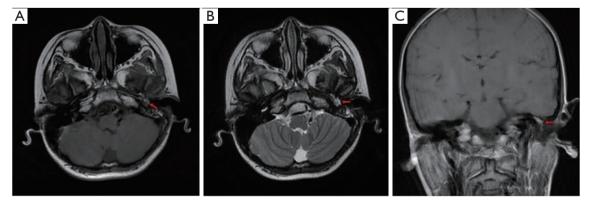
Preoperative MRI. (A) *T1WI*, axial. (B) *T2WI*, axial. (C) Enhanced *T1WI*, coronal. The red arrow indicates the lesion site. MRI, magnetic resonance imaging; T1WI, T1 weighted image; T2WI, T2 weighted image.
